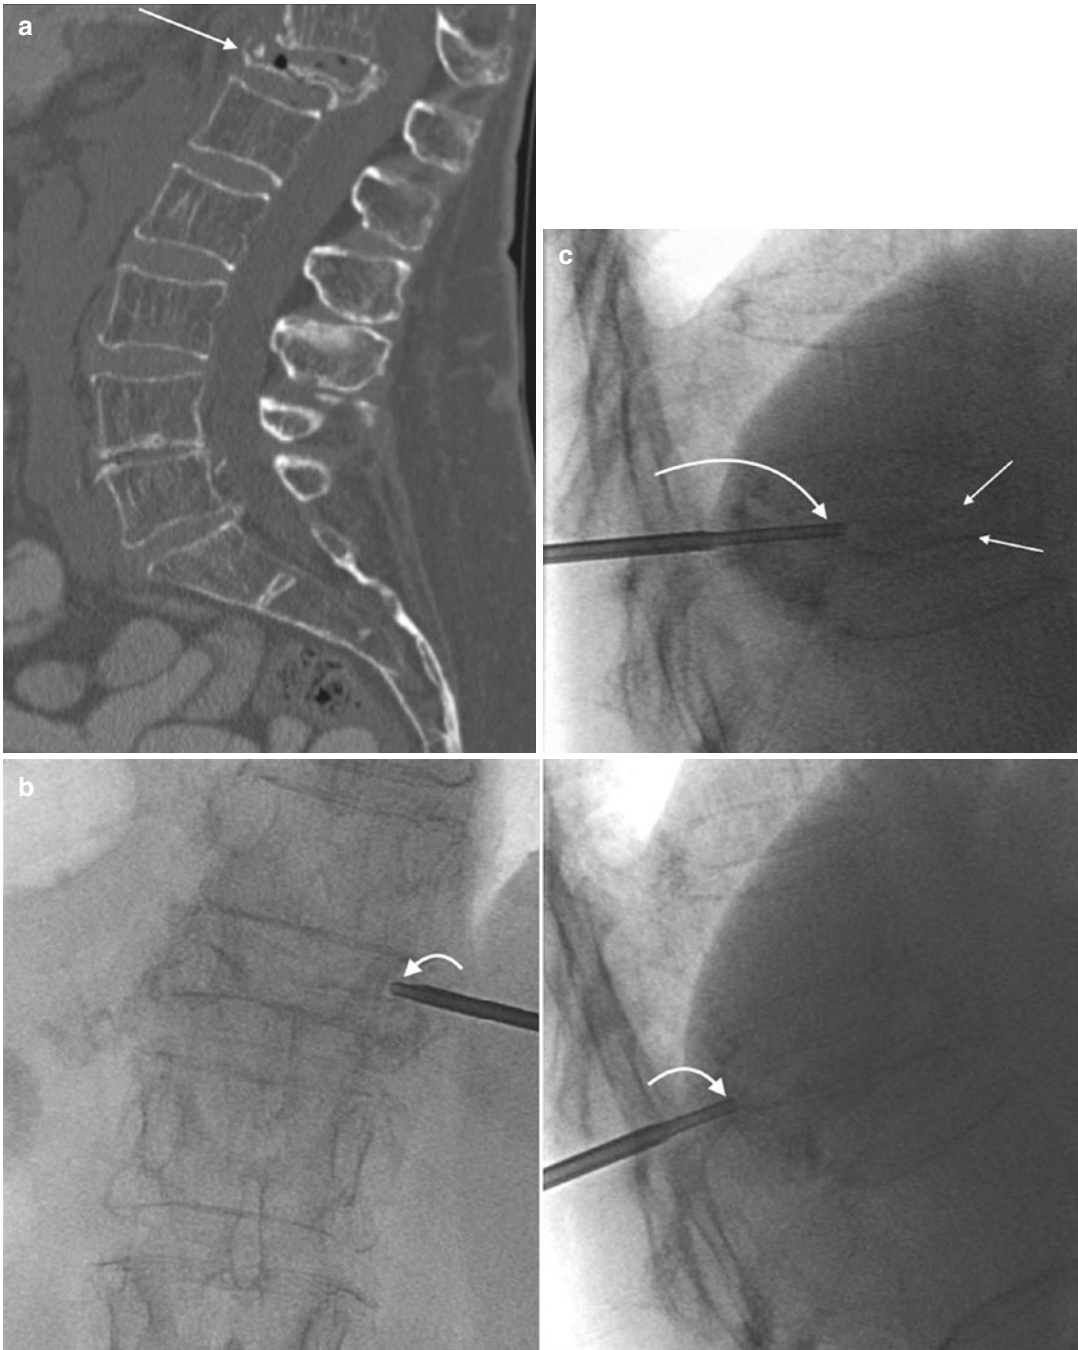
A 77-year-old female with chronic, severe low back pain. Reformatted sagittal CT image (a) in bone window algorithm shows a vertebra plana deformity of the T12 vertebral body (arrow) with small amounts of gas with the anterior vertebral body and adjacent disk space; mild bone retropulsion into the spinal canal is noted as is focal kyphosis. Marked osteopenia is seen. Biplane fluoroscopic images (b) in the frontal and lateral projection
